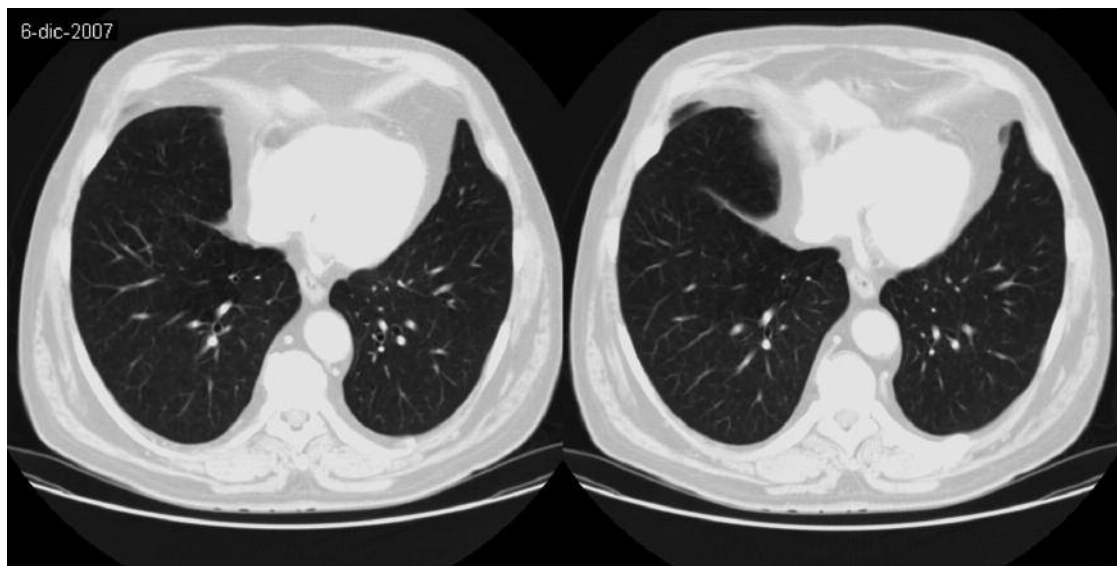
The most recent restaging CT scan showing the persistence of the complete remission of lung metastases after 19 months (December 2007).
